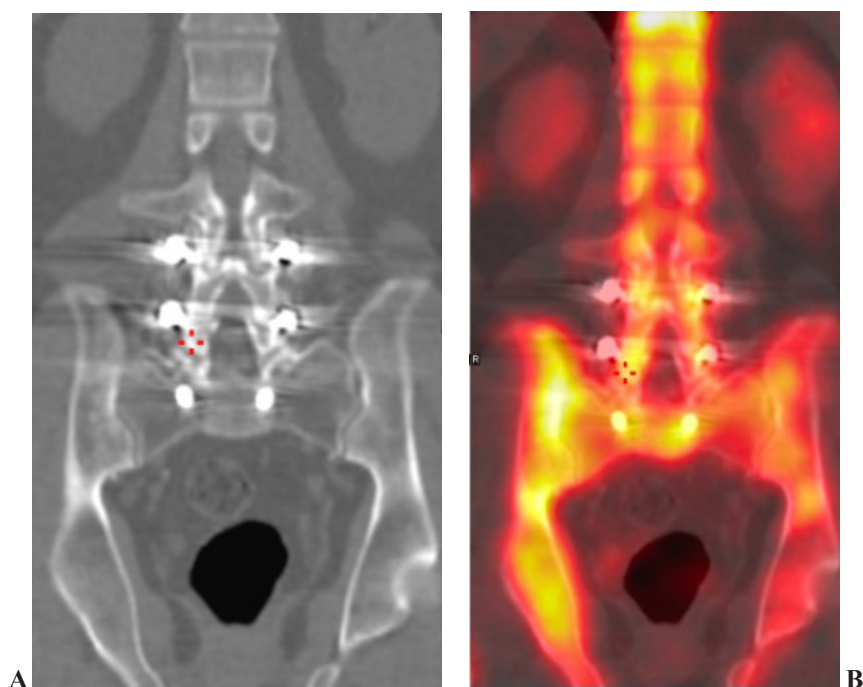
Chronic right-side pain and sacro-ileitis in a patient undergone posterior fixation. Coronal CT 2D recon demonstrates transpeduncular screws at the level of L4, L5 and S1, in a patient treated 5 years before with surgical posterior fixation. No significant bone abnormality can be detected on CT scan (1a). On SPECT-CT scan, evident Tc99 uptake can be detected at the level of right SIJ area as well as right iliac bone, secondary to posterior fixation (1b).
